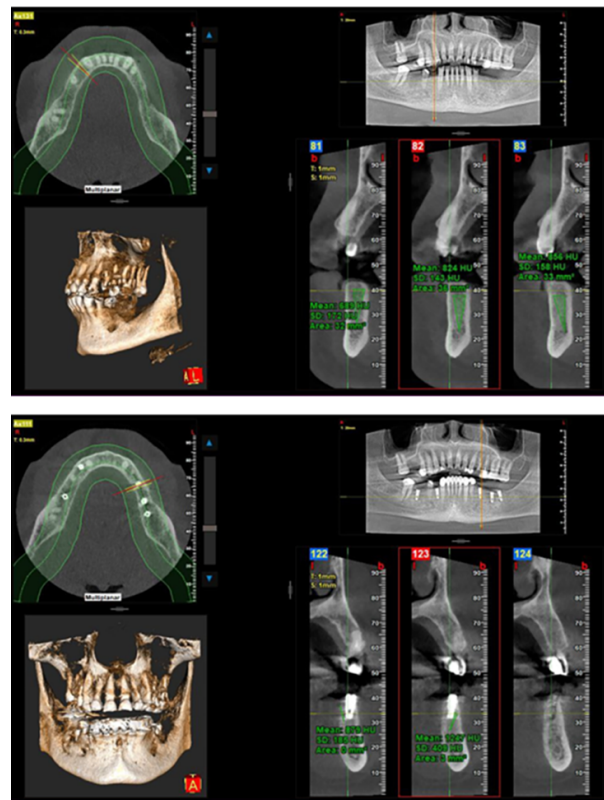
Preoperative (Upper View) and Postoperative (Lower View) CBCT for Both Lower First Premolar and Lower First Molar. They Provide the Pre and Postoperative Mean Bone Density Values in HU.
